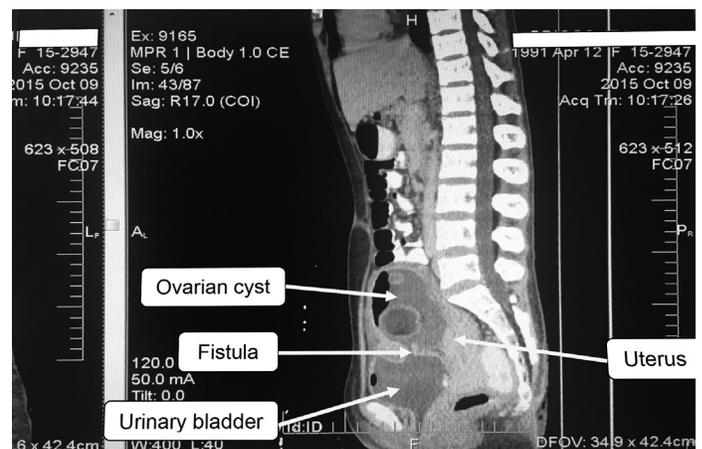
Patient's CT scan with contrast showing communication between the dermoid cyst and the urinary bladder.
